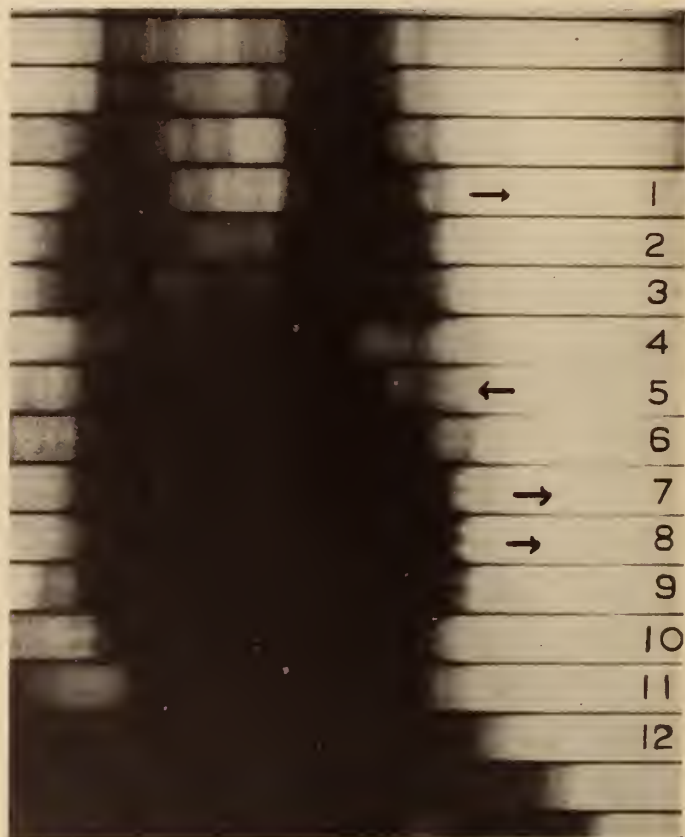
Roentgenkymogram in L-O View: Segment 1, normal pulsation of the descending aorta; segments 5-6, normal pulsation of upper left ventricular border; segments 7-10, comprising lower two-thirds of left ventricular border—complete reversal of pulsation, i.e., there is an outthrust during systole, synchronous with the inthrust of the normal ventricle and outthrust of the aorta.
